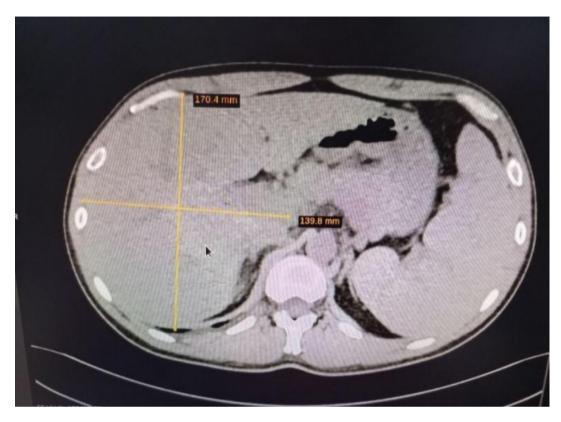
An abdominal CT scan with enlarged liver, and enlarged spleen due to HLH
